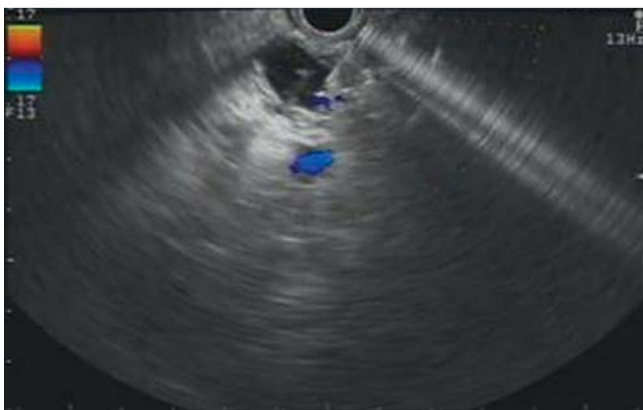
Endoscopic ultrasound (EUS) image of the main pancreatic duct punctured by the 19-gauge needle.
